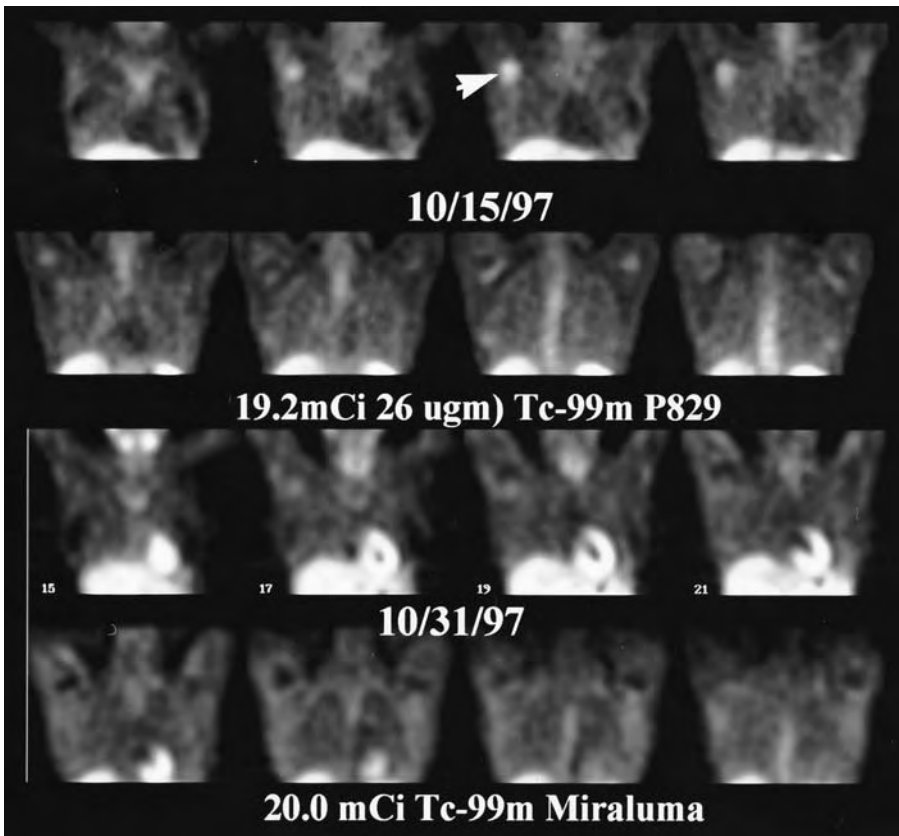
^{99m}Tc -P829 scintigraphy indicates in a patient with breast cancer (primary tumor resected) axillary lymph node recurrence (*arrow, upper two rows*) 1.5 h after injection of 50 μg (700 MBq) radioligand (SPECT; coronal reconstruction). Scintigraphy with Sestamibi (Miraluma, Dupont Pharma, Billerica, Mass.) showed only faint uptake (*lower two rows*). (Courtesy of H. Handmaker)
